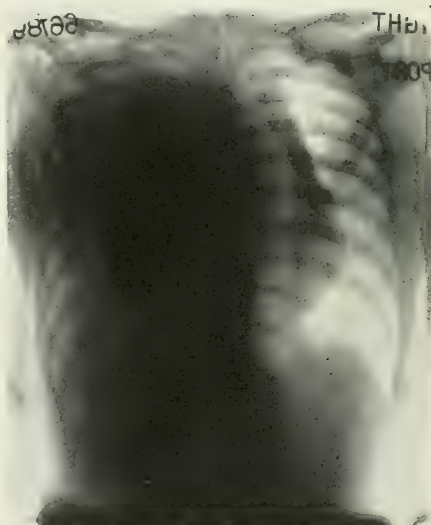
Case IV. Plate 1. Abscess with empyema necessitatis. X-ray on admission showing enormous fluid collection on left side with great heart displacement to the right. The abscess on the chest wall doesn't show. Hæmolytic streptococci and innumerable tubercle bacilli were found in the pus.
